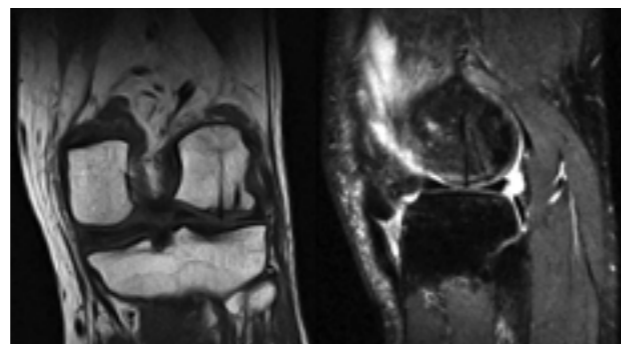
Bony-cartilaginous fracture of the femoral condyle: A — radiographs of the knee joint: the shadow of the fragment is observed on the lateral projection near the lower pole of the patella; B — bone and cartilage fragment; C, fragment fixation with biodegradable pins; D — fragment fixation with biodegradable pins; E, MRI of the knee joint. No interference from implants
